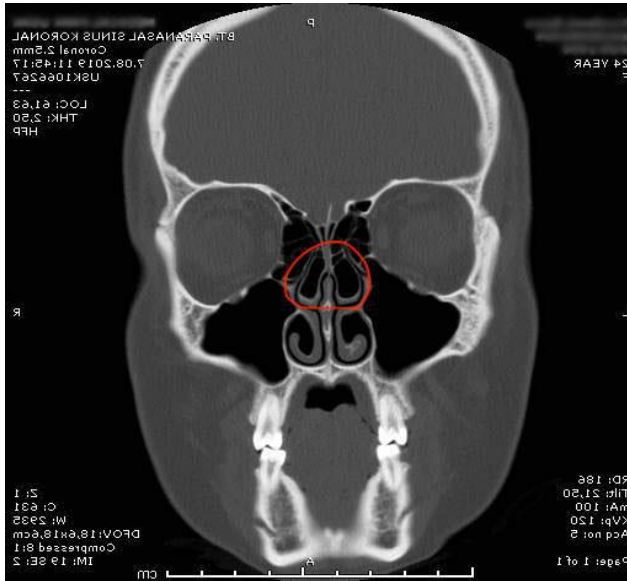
Paranasal sinus computed tomography image of both middle turbinates pneumatization. (Case 1, marked area)
